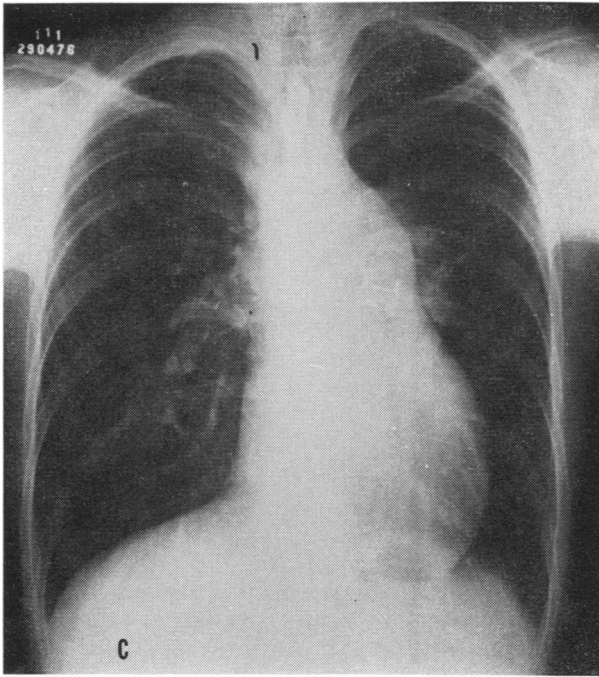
A and B: Preoperative frontal and lateral Roentgenograms of the chest. Dilatation of the pulmonary artery and its branches. C and D: Postoperative frontal and lateral Roentgenograms showing the homologous duramater prosthesis in the pulmonary annulus.
